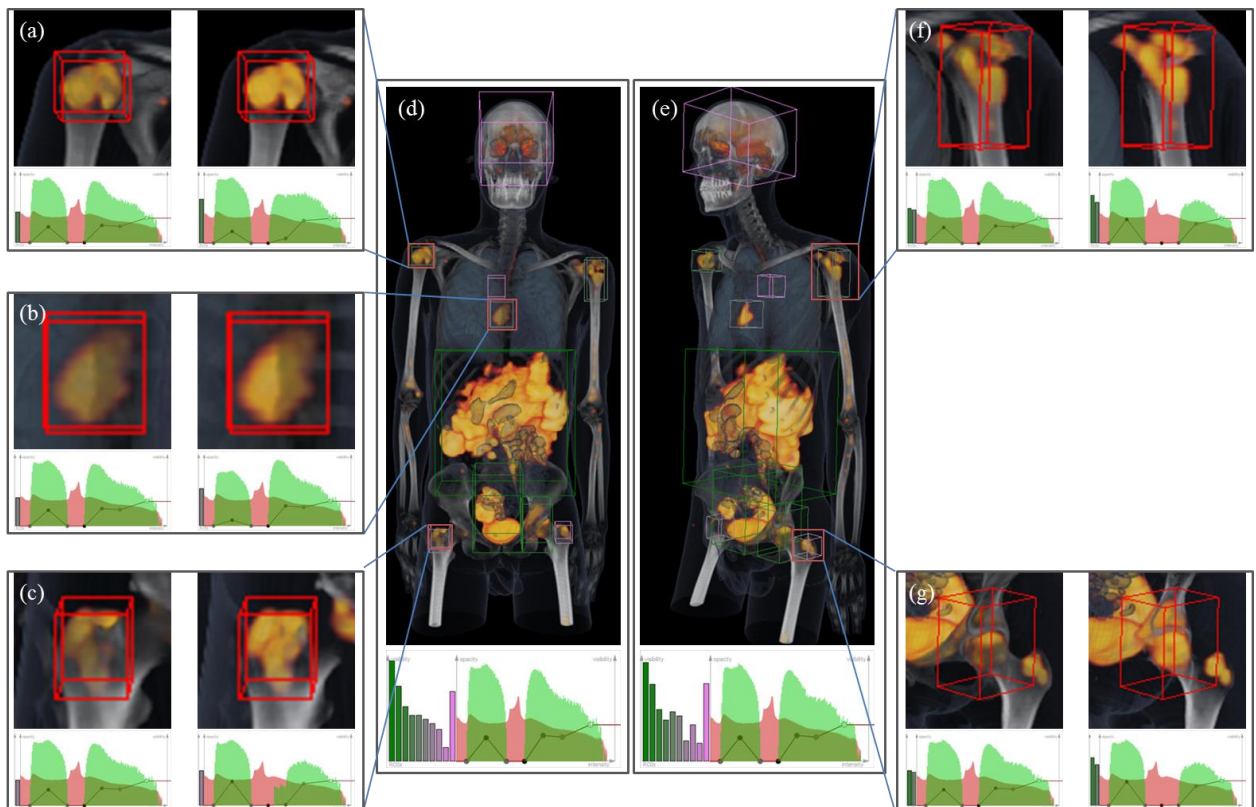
A PET-CT study of disseminated disease consistent with a high-grade lymphoma, consisting of multiple abnormalities spread throughout the body. Our transfer function automation is used to visualise the different abnormalities based on the user-selected ROIs in (a) to (c) and multiple ROI selections of (f) and (g).
